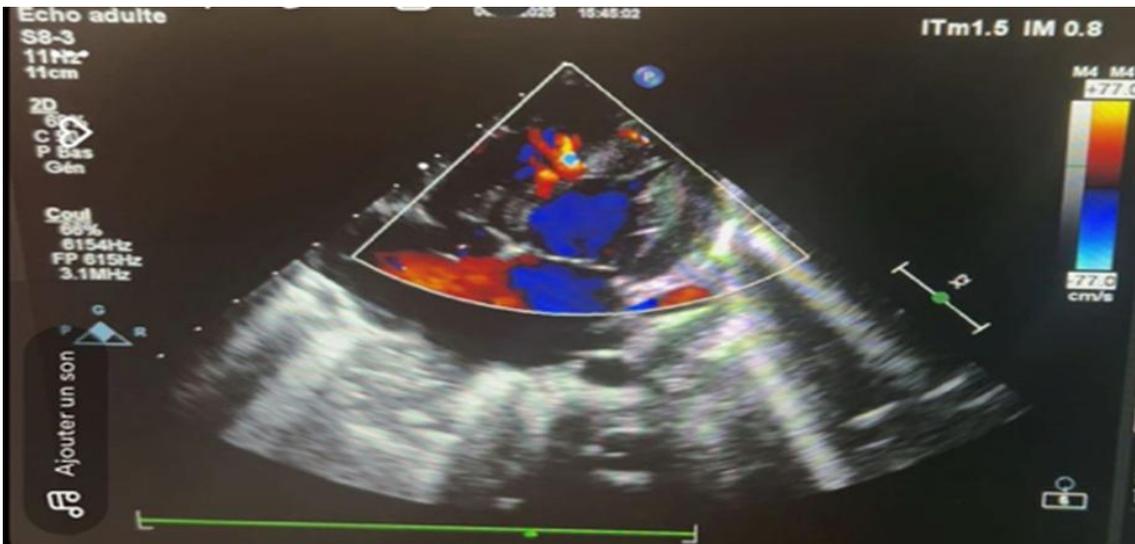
Appearance of three ventricular septal defects in color Doppler mode (note the left-to-right shunt).
